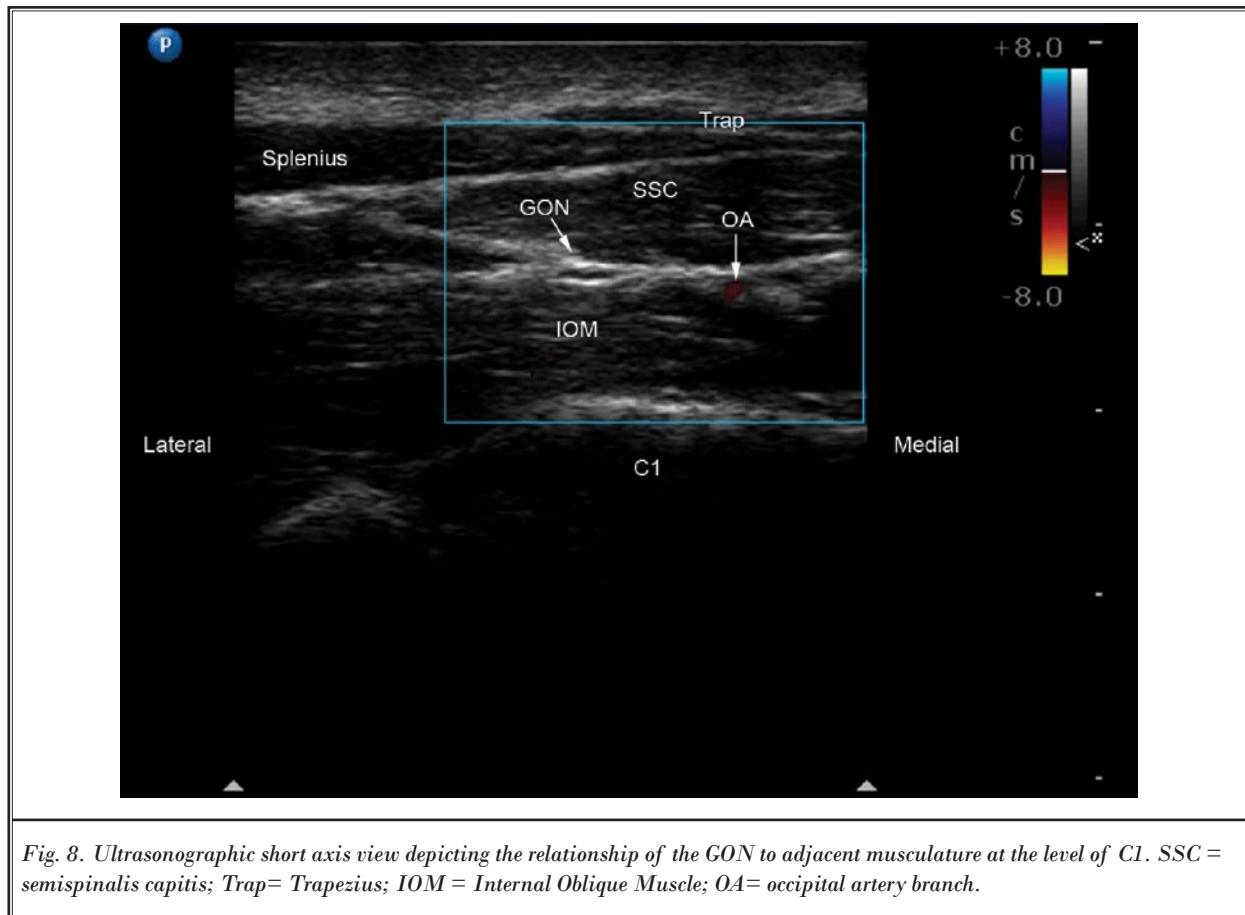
Ultrasonographic short axis view depicting the relationship of the GON to adjacent musculature at the level of C1. SSC = semispinalis capitis; Trap= Trapezius; IOM = Internal Oblique Muscle; OA= occipital artery branch.
